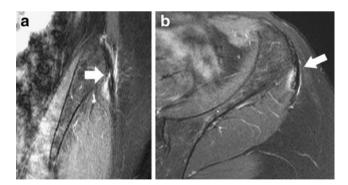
Coronal (a) and axial (b) fat-suppressed T2-weighted images obtained using a 3 T MRI in a 50-year-old female runner with pain at the level of the iliac tubercle. Perifascial bright T2 signal (*arrows*) surrounds the proximal ITB near its enthesis. A medial surface partial tear just distal to the iliac tubercle is indicated by the *arrow* in the coronal plane (a)
